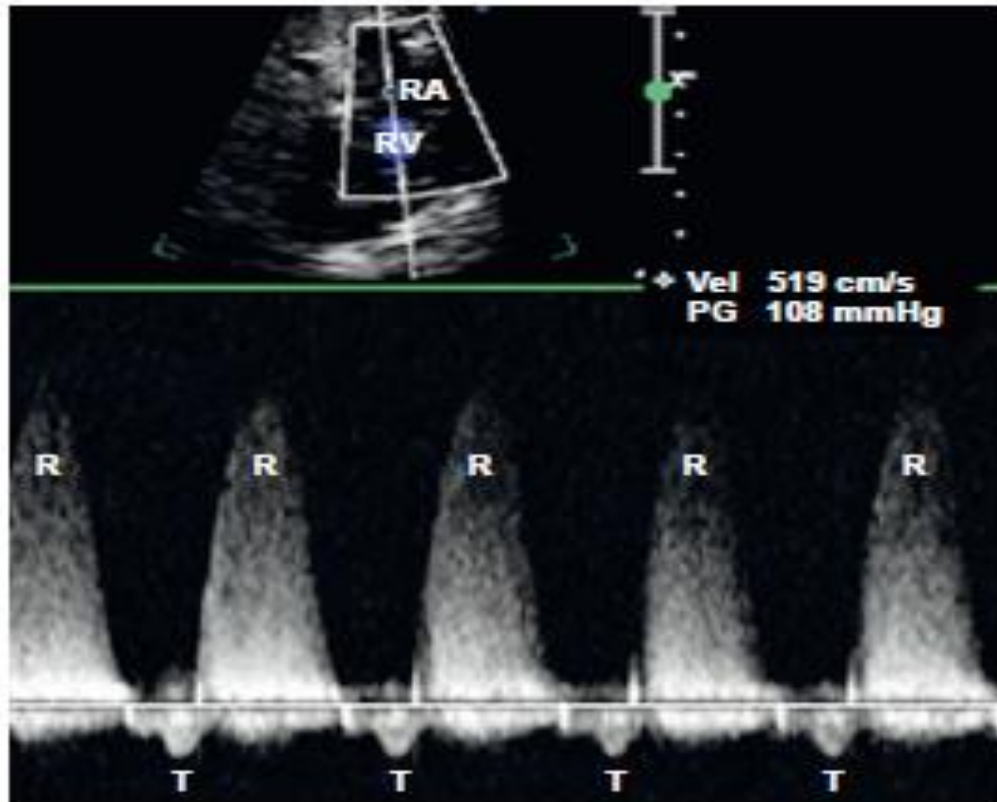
Tricuspid Insufficiency. Spectral Doppler sample volume is placed proximal to the tricuspid valve in the right atrium (*RA*). The regurgitant flow (*R*) can be seen above the baseline. This implies that the valve has not closed completely during systole, and therefore blood flow is retrograde into the right atrium. *RV*, Right ventricle; *T*, tricuspid valve.
